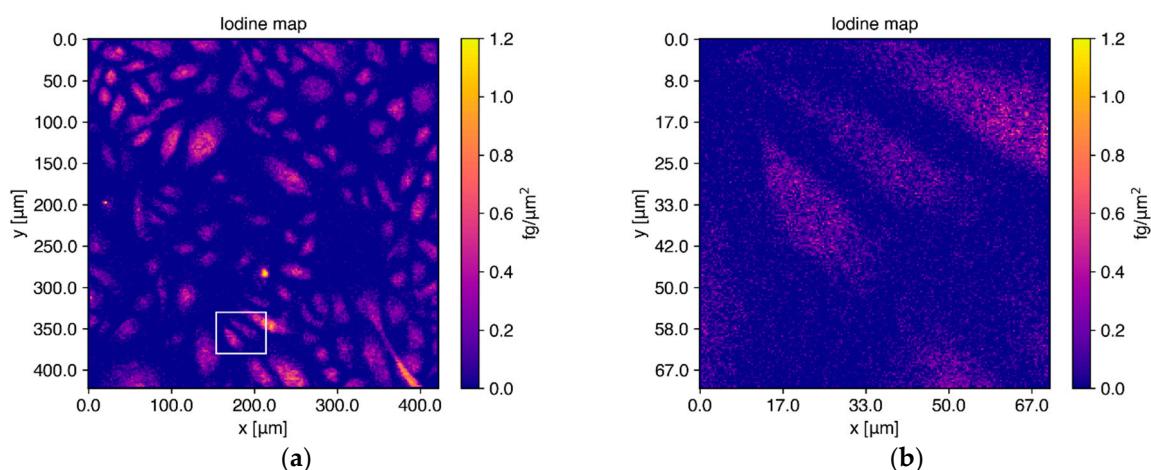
Elemental maps for iodine reconstructed from single-cell measurements after I₂-Q₁₀ treatment. (a) Cells from donor 1 on a silicon nitride membrane were scanned with a 12 keV X-ray beam over an area of $420 \times 420 \mu\text{m}^2$. Iodine (as labeled to Q₁₀) is distributed homogeneously inside the cells. (b) Elemental maps of 3 cells from the same membrane scanned again with higher resolution, showing the distributions found in (a) in more detail. The scan area is indicated with a white rectangle in the elemental map shown in (a).
